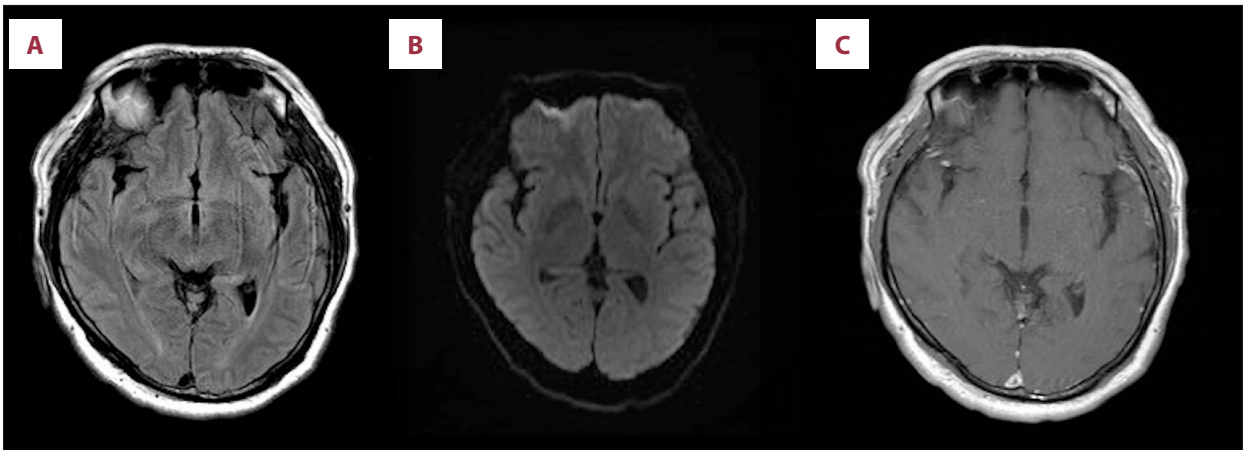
Brain magnetic resonance imaging (MRI) findings after 4 weeks of IV ceftriaxone. (A) Fluid-attenuated inversion recovery (FLAIR). (B) Diffusion-weighted images (DWI). (C) Post-contrast, 18 mL of gadopentetate dimeglumine (Magnevist).
